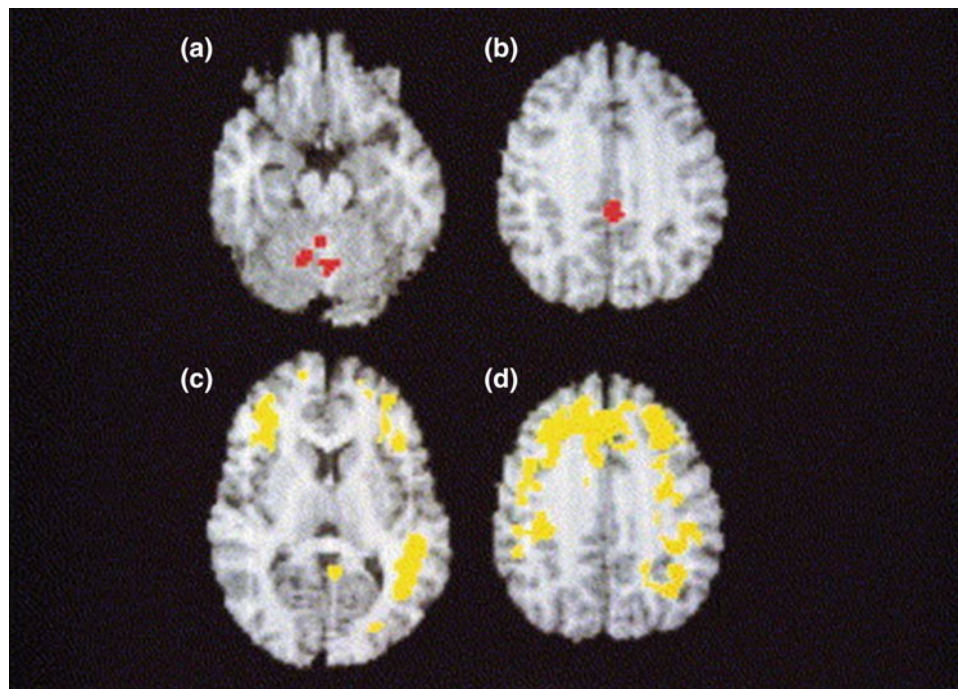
SPECT findings during sleepwalking after integration into the appropriate anatomic magnetic resonance image. The highest increases of regional CBF (>25 %) during sleepwalking compared with quiet stage 3–4 NREM sleep are found in the anterior cerebellum (i.e., vermis) (a), and in the posterior cingulate cortex (b). However, as compared to data from normal volunteers during wakefulness, large
